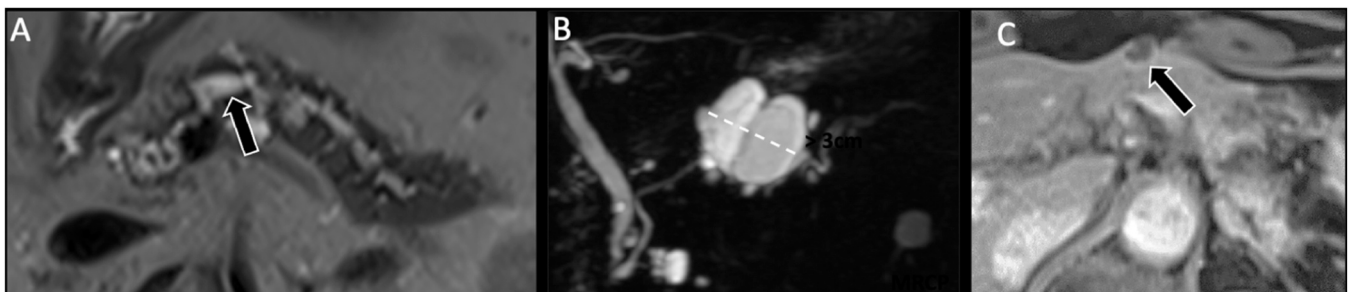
Examples of worrisome features in different patients. A. T2-weighted non-fat sat sequence in the axial plane shows a dilated main pancreatic duct (arrow) of up to 7 mm. B. Coronal MRCP image shows a cyst that is larger than 3 cm. C. Contrast-enhanced T1-weighted MR image shows a thin enhancing wall.
